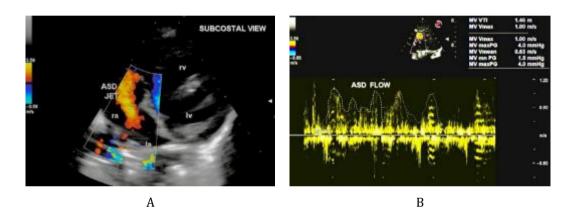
(A) In the subcostal view an ASD jet is exhibited. (B) On pulse wave doppler analysis across ASD, peak/mean gradient was 4.0/1.8 mmHg.
